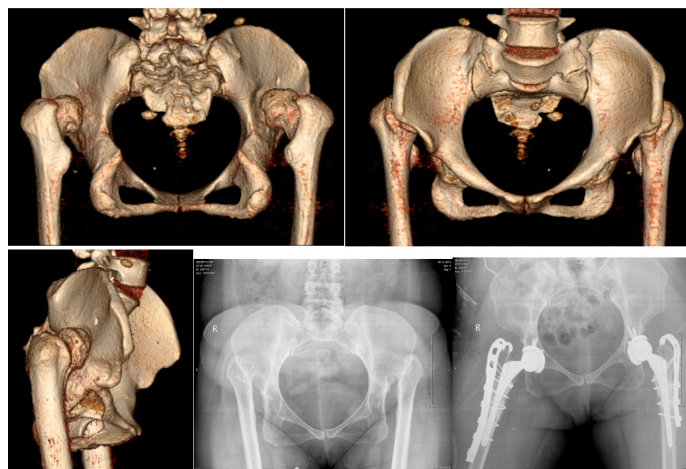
Bilateral Crowe type IV patient 3-d CT images, preoperative and postoperative final images
